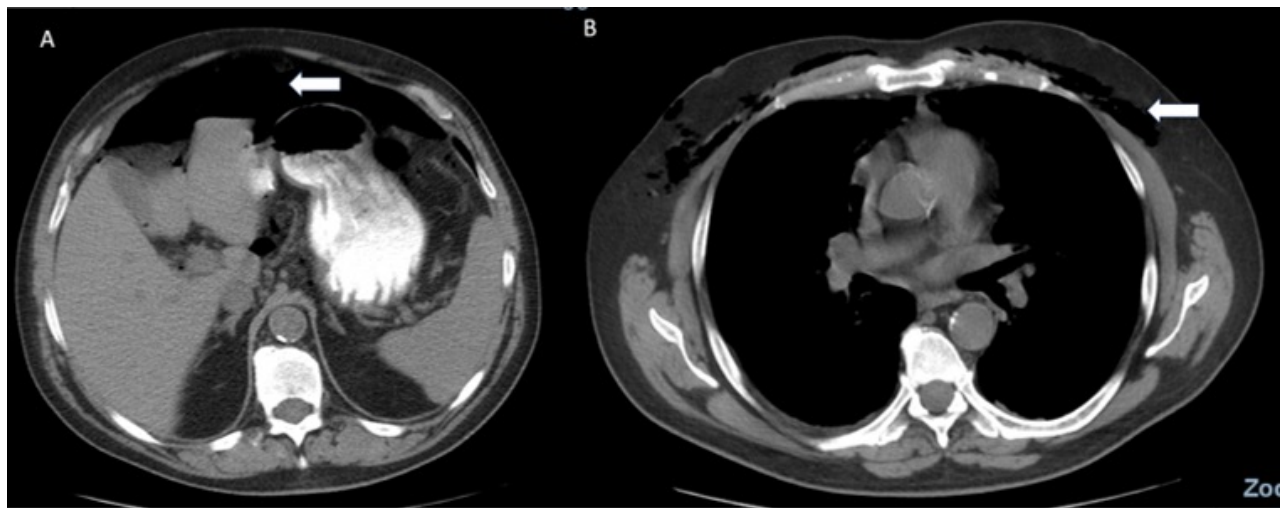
Computed tomography scan in patient 5 showing a) pneumoperitoneum; b) subcutaneous emphysema (white arrows)
